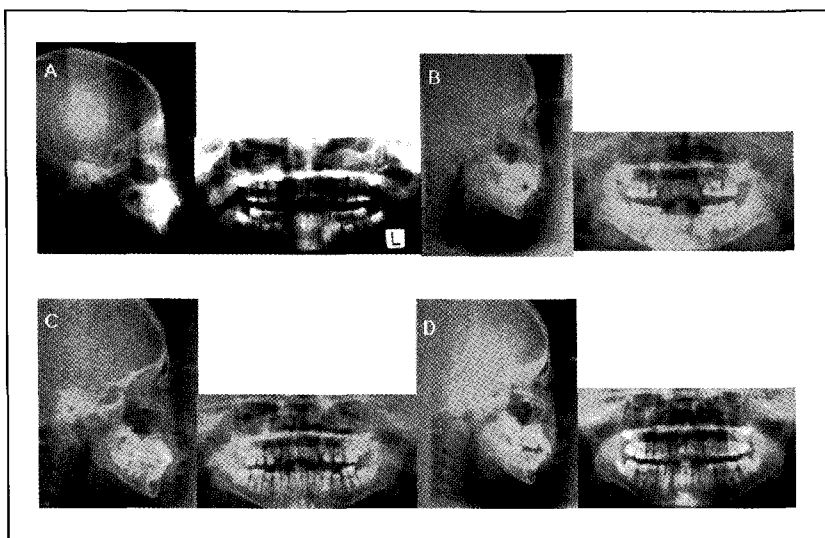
Cephalometric and panoramic radiographs: (A) Pretreatment; (B) after Fränkels appliance and cervical pull headgear therapy; (C) after C-activator treatment; (D) posttreatment.
